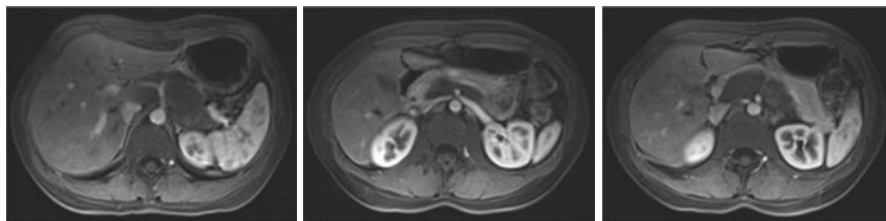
A 32-year-old female patient had a preaortic retroperitoneal mass found during a routine abdominal ultrasound. MRI shows a solid expansive lesion, poorly vascularized, with lobulated contours and well-defined limits measuring $8.2 \times 5.0 \times 4.1$ cm, located in the retroperitoneum, displacing the pancreas anteriorly and maintaining contact with the left adrenal gland. The lesion involves the celiac trunk and its branches, which are patent, with normal caliber and regular contours. It also maintains contact with the superior mesenteric artery and the inferior vena cava and has a compressive effect on the splenic vein. An image-guided biopsy was performed and revealed the diagnosis of ganglioneuroma. The patient has been in follow-up for 5 years, asymptomatic, with imaging tests demonstrating the stability of the lesion
